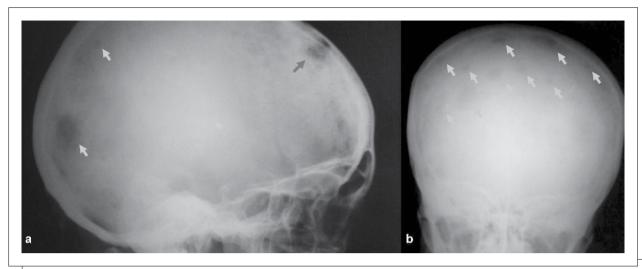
a. X-ray latero-lateral incidence of the skull, revealing radiolucent areas that represent the osteolytic lesions (yellow arrows). The red arrow shows the osteolytic lesion in the topography underlying the most significant skin nodule, suggesting the lesion origin. b. X-ray postero-anterior incidence of the skull, evidencing several osteolytic lesions (yellow arrows).
